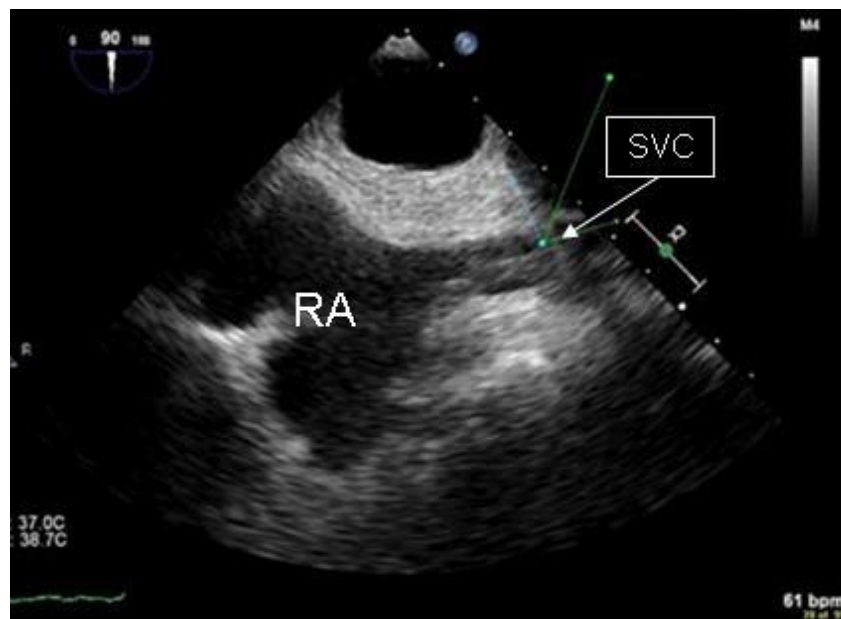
Transesophageal echocardiography demonstrating the VA shunt remnant fibrosed (vs. calcified) in SVC (arrow) extending into right atrium (RA).
